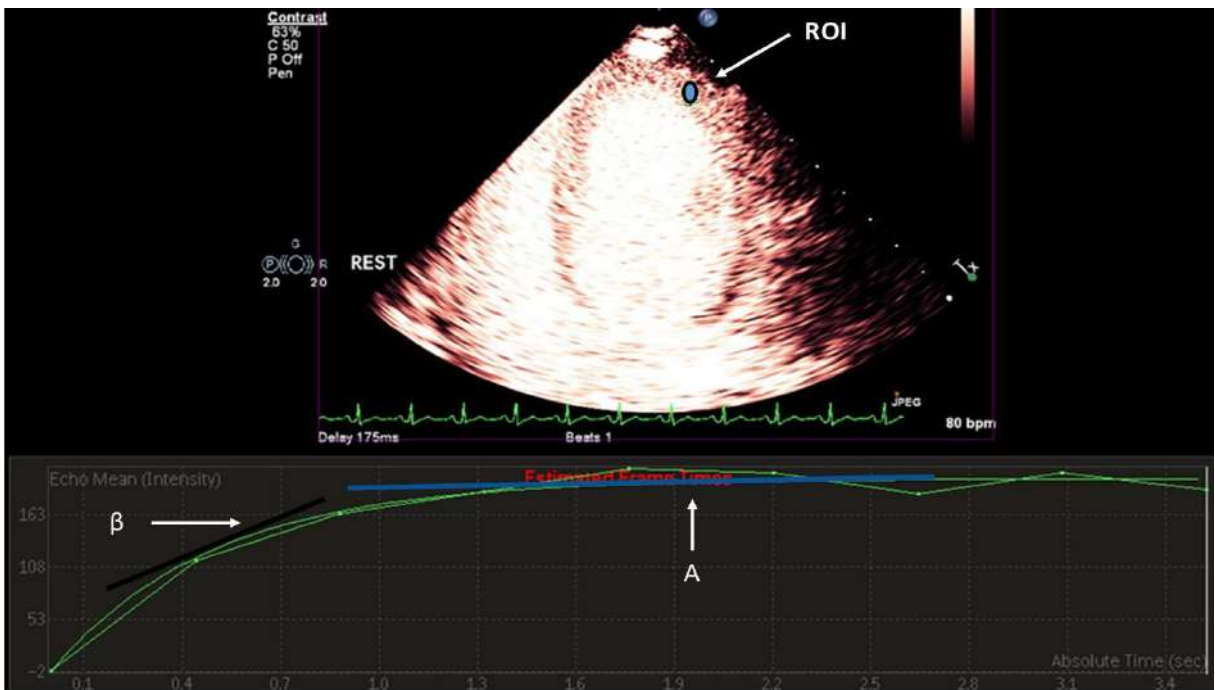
Example of myocardial contrast echocardiography quantification output from the Philips QLab system. ROI – region of interest.
